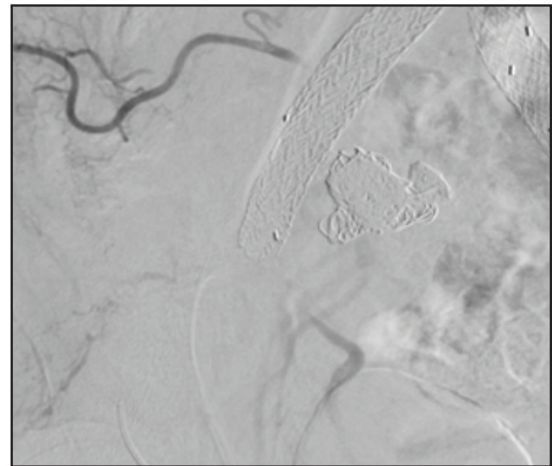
Late arterial phase CTA showing stagnation of the contrast media in the right deep circumflex iliac artery as well as in the right obturator artery (supplied by the right inferior superficial epigastric artery through the corona mortis anastomotic arch). The image demonstrates optimal packing and total occlusion of the aneurysmal sac, helping decrease the chances of retrograde filling from the other supplying arteries.
